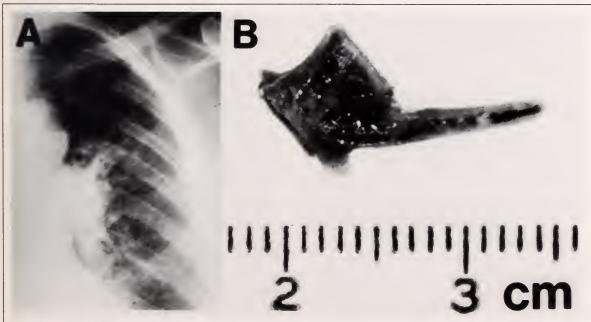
A. Chest radiograph showing left hilar mass suspicious for malignancy.
